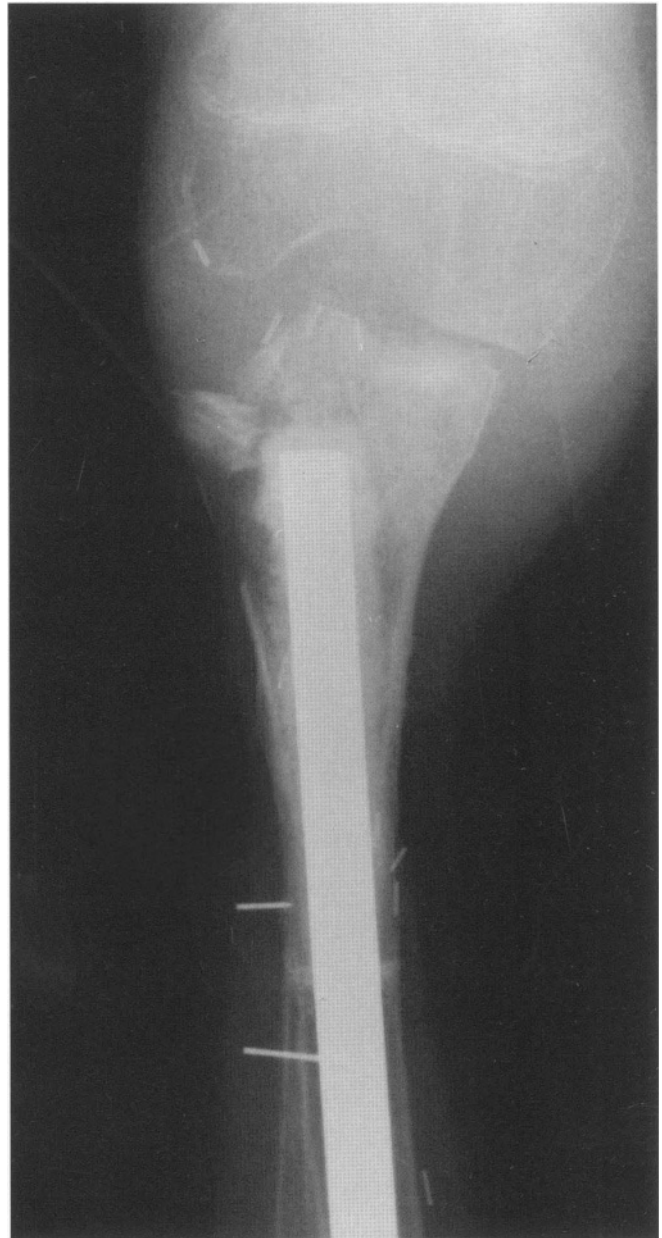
Allograft replacement. Plain radiograph 4 years following a proximal tibial allograft replacement. Note the allograft failure with collapse of the articular surface and resorption of the proximal tibial component. This patient was salvaged by a proximal tibial prosthetic replacement. In general, the authors do not recommend allograft replacements and prefer prosthetic reconstruction.
